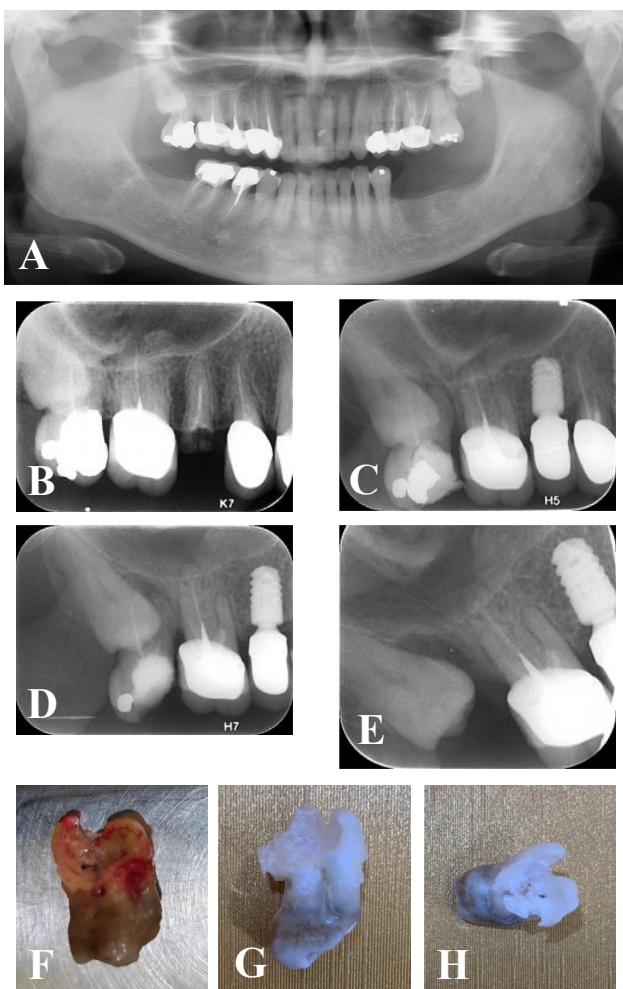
A series of radiographs and clinical photographs showing the severe external root resorption of the tooth 17 caused by the pressure from the impacted wisdom tooth 18 in our case. (A) The panoramic radiograph taken in October 2009 revealed the impacted tooth 18, severely squeezing the root of tooth 17. (B and C) The periapical radiographs taken in March 2015 and March 2022, respectively still revealed the same condition. (D) The periapical radiograph taken in March 2025 showed that the crown of tooth 18 took up the space of the root of tooth 17. (E) The periapical radiograph taken after the extraction of tooth 17 exhibited that the crown of tooth 18 was located in the extracted socket of tooth 17. (F) From the sagittal view of the extracted tooth 17, there was a clear circular indentation on the root side. (G and H) After soaking in bleach, the root surface of the tooth 17 undergoing external root resorption could be clearly observed and the apex of the disto-buccal root had completely disappeared.
